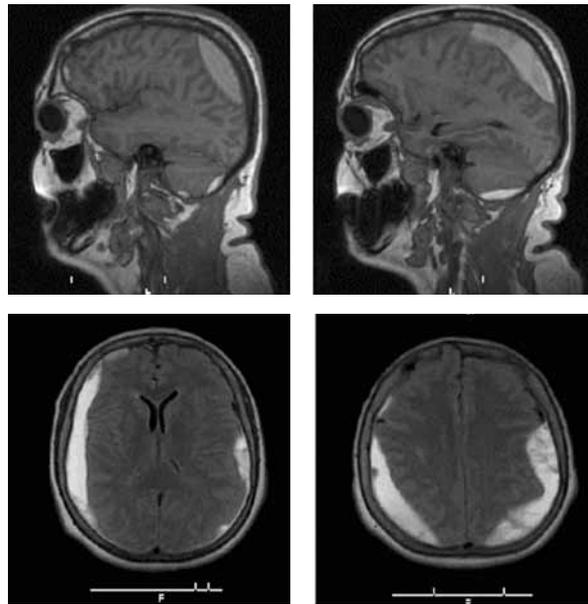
MRI of the brain before the operation
